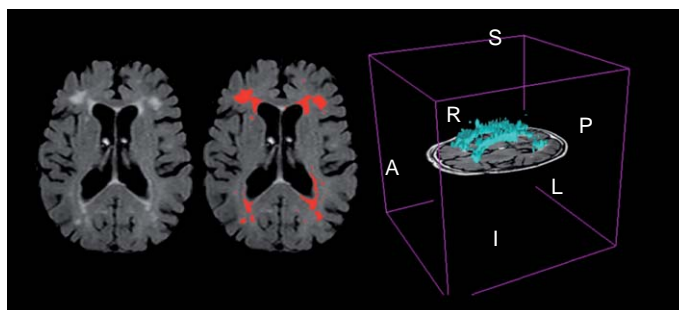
White matter hyperintensity surrounding ventricular cavity and extending into prefrontal region in patient with AD. Left: skull-stripped FLAIR image. Middle: Computer algorithm identifies hyperintensity regions. Right: Hyperintensities represented in three dimensions in cyan. Note shape similar to ventricular cavity.
